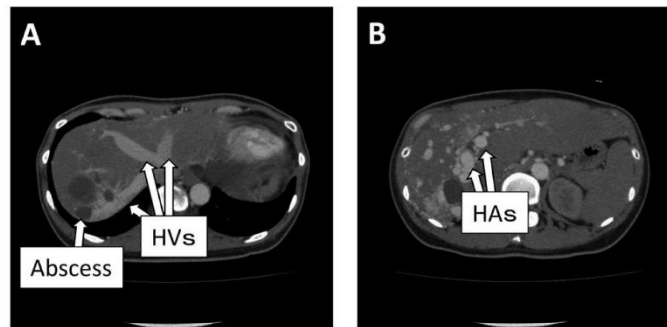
Contrast-enhanced CT of patient 2. (A) The intrahepatic veins were vigorously enhanced even in the very early phase of contrast-enhanced CT. (B) The hepatic arteries enormously enlarged to nearly the size of the aorta.
